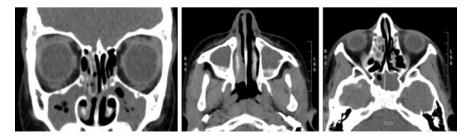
Computed tomography scan of paranasal sinuses showing right inferior turbinate enlargement, an almost complete bilateral sphenoid and maxillary sinuses opacification, and a right anterior ethmoid sinus partial opacification
